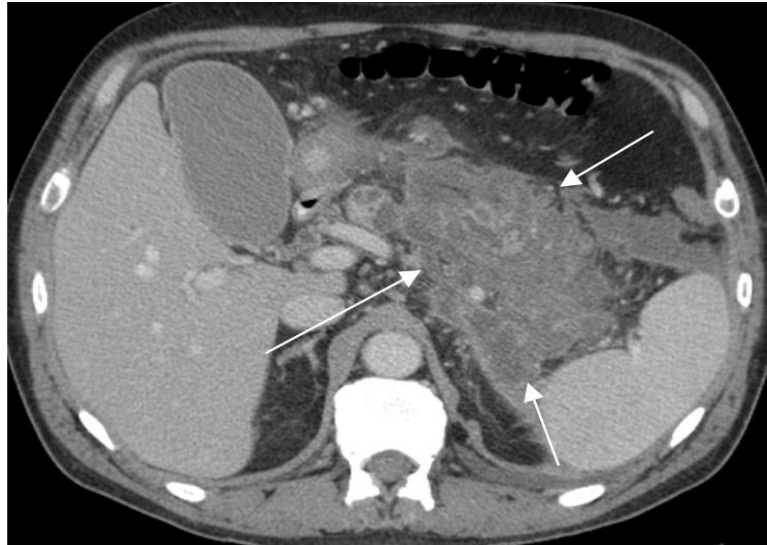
CT scan of patient M., 49 years, 13 hours from the onset. There is a total pancreatic necrosis and PPT necrosis.
